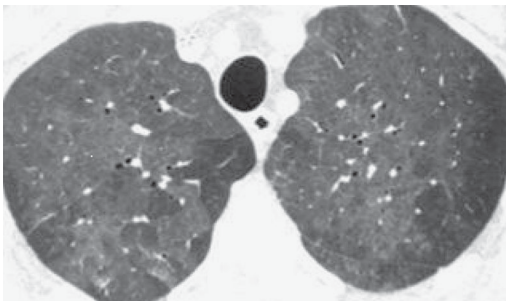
CT chest demonstrating typical diffuse bilateral ground glass opacities.
